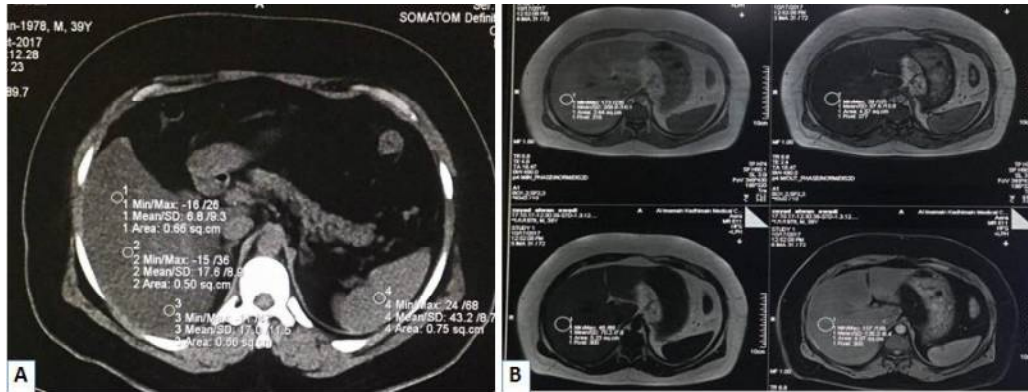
39 years old male, diabetic with elevated liver enzymes (ALT 115U\L, AST 82U\L). A: CT scan shows fatty liver (hepatic attenuation is 10HU, spleen attenuation is 43 HU). B: MRI Dixon show the calculated hepatic FF is 38%.
